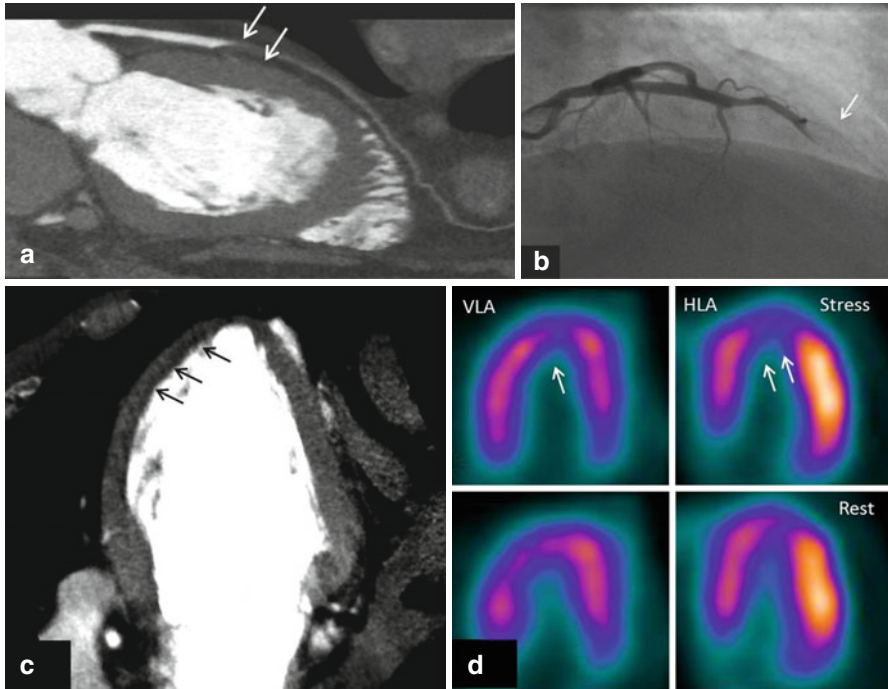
Figures represent combined coronary CTA and myocardial CTP imaging showing flow-limiting stenosis confirmed by invasive coronary angiography and SPECT. CTA (panel-a) shows total occlusion of mid-LAD with corresponding CT hypoattenuation (panel-c, *black arrows*) involving anterior, anteroseptal, and apical myocardial segments consistent with myocardial CTP deficit. Panel b shows complete occlusion (100 % lesion) of mid-LAD on invasive coronary angiography with concurrent SPECT perfusion (panel d) defects read in similar myocardial segments as CTP
